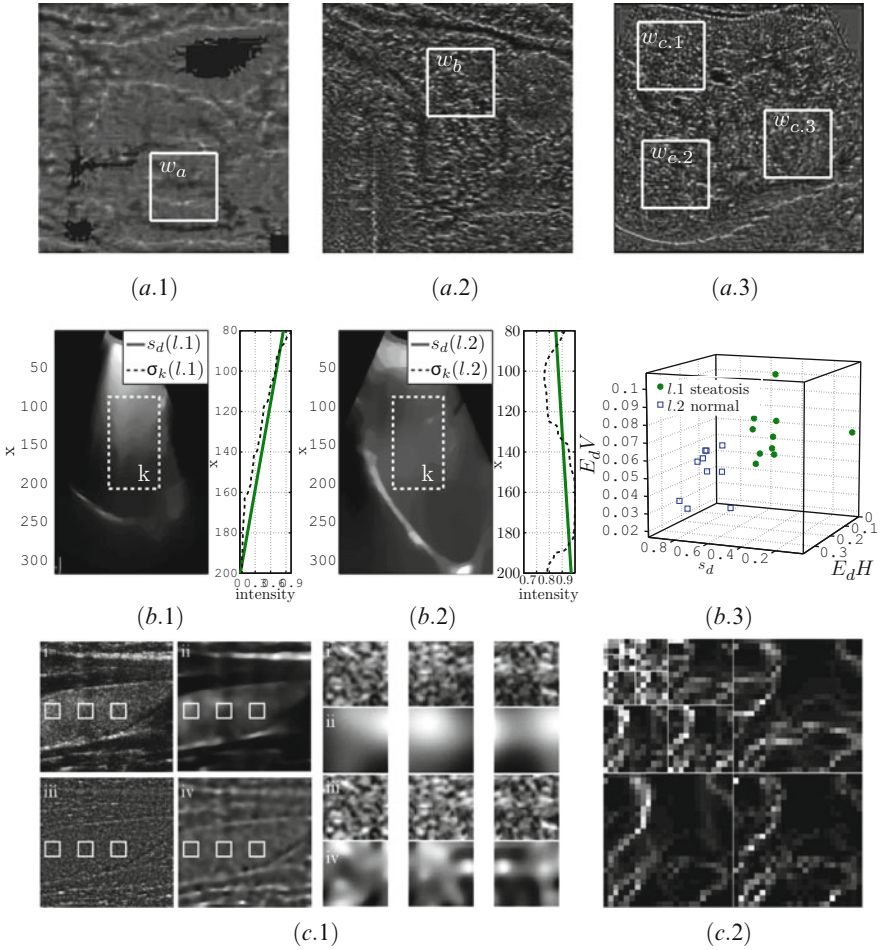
Feature extraction based on ultrasound speckle decomposition applied to different case studies. (a) first Haar wavelet energies based on speckle from plaque (1), thyroid (2), and liver (3). (b) feature based on *echogenicity decay* (1–2) and feature space of normal and steatotic livers. (c) Sample extraction from noiseless and speckle components, obtained from thyroid images (1); wavelet decomposition from speckle field (2)
